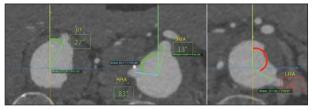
Preoperative CT scan with the evaluation of the horizontal angles of renovisceral arteries.
